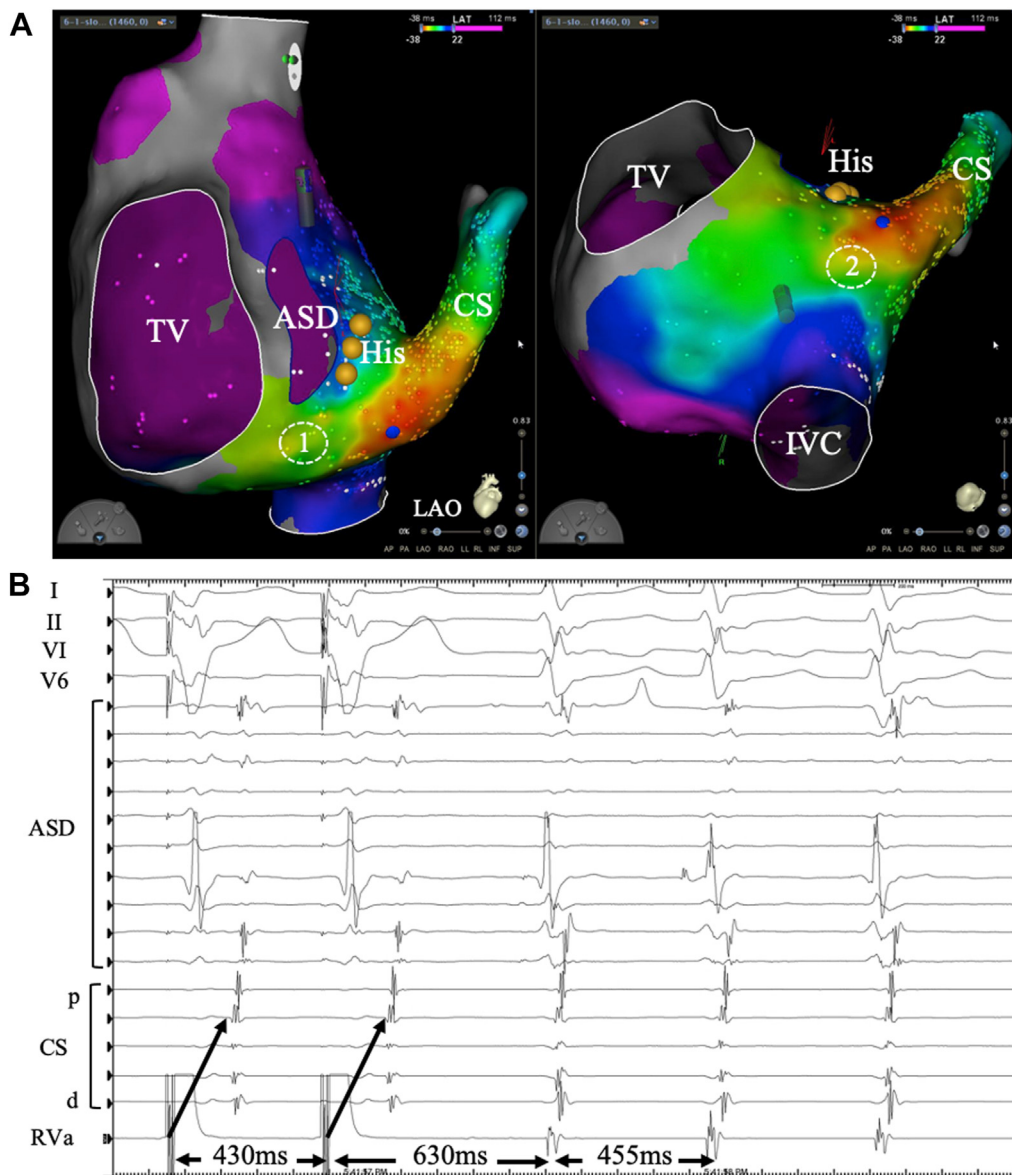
A: Activation mapping obtained during supraventricular tachycardia (SVT) #1, with broad early activation at the anterior-inferior lip of the coronary sinus. The atrial septal defect (ASD) location is manually contoured using intracardiac echocardiography. The location of His bundle electrograms (yellow dots) is displaced inferoposteriorly from its usual location by the ASD. The site of earliest fast pathway activation is represented by the blue dot. The duodecapolar catheter (PR) is positioned along the superior septal tricuspid annulus. The 2 areas of empiric cryoablation are represented by the stippled regions 1 and 2. B: Ventricular overdrive pacing is performed during SVT #1. See text for details. CS = coronary sinus; IVC = inferior vena cava; LAO = left anterior oblique; TV = tricuspid valve.
